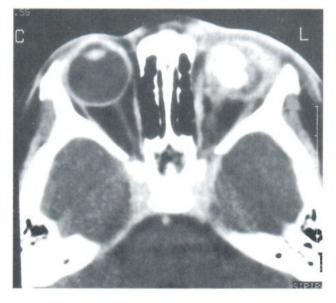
This is a unilateral retinoblastoma with uveal-scleral tissue invasion. CT depicted as irregular, nonuniform thickening of ocular wall of left eye.
